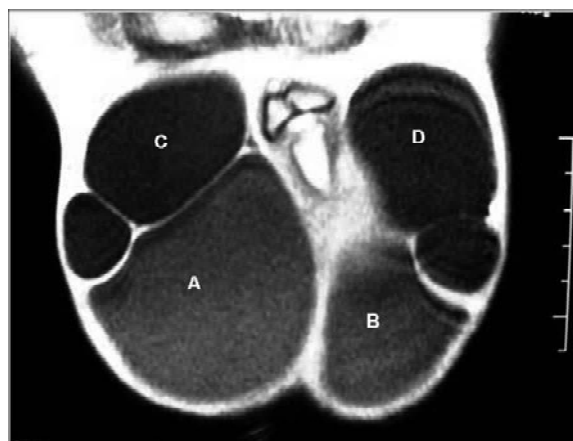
MRI (T1) showing bilateral hydroceles (A, B) and bilateral spermatoceles (C, D).
